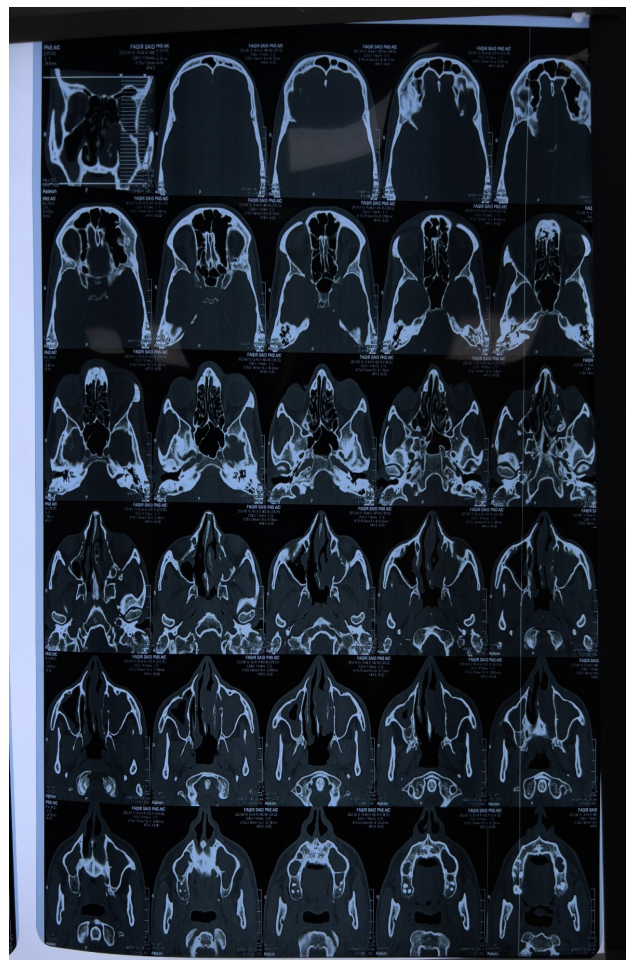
CT Nose and Paranasal Sinuses. showing left Antro -Choanal Polyp
